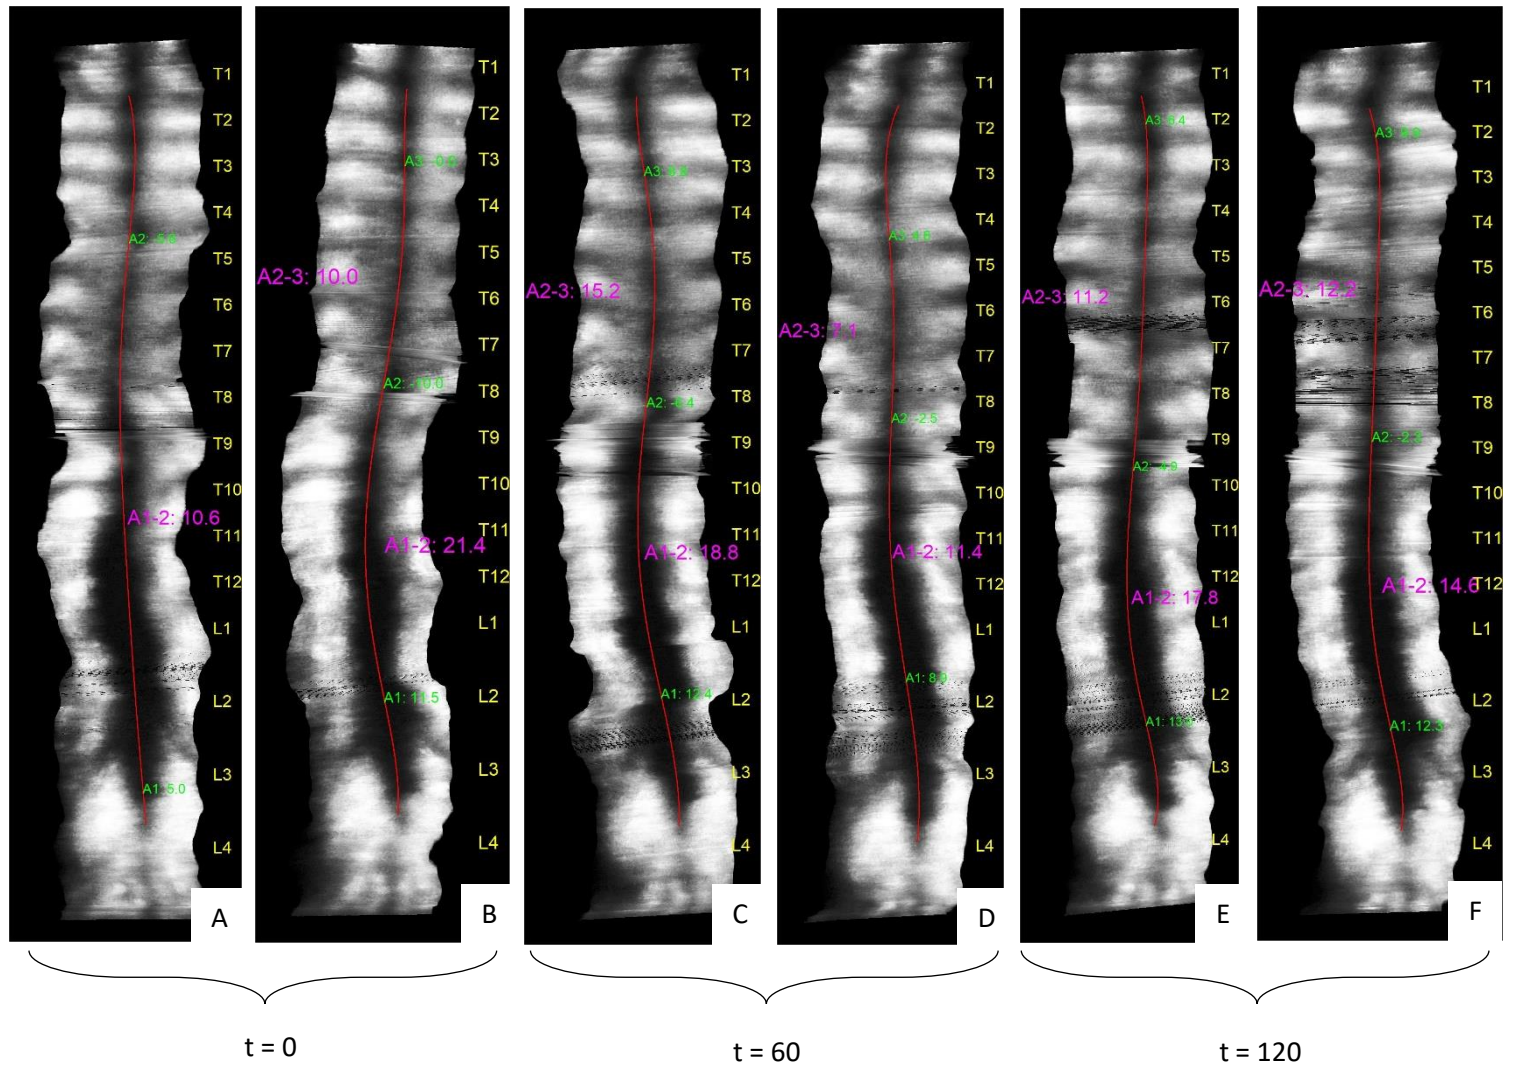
Posterior view of the ultrasound image results, all cuffs inflated to 100 mmHg. Image A-B, C-D and E-F were taken right after each other with a time difference of 60 minutes between them. Pressures are applied in the same direction as figure 15. A1-2 represents the thoracolumbar curve, A2-3 represents the thoracic curve.
